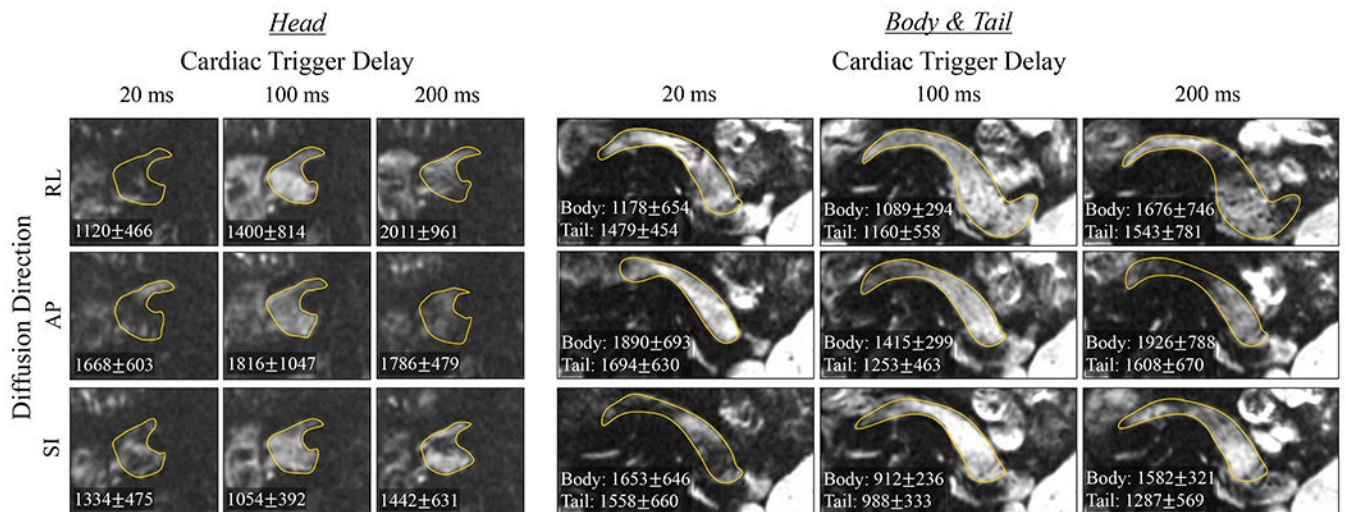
Single-slice monopolar-based diffusion-weighted images with $b = 500 \text{ s/mm}^2$ in three diffusion directions. DWI was obtained at three different cardiac trigger delays, each acquired in a separate breath hold. The yellow contours were drawn from the T2-weighted image ($b = 0 \text{ s/mm}^2$, not shown) and overlaid on DWI $b = 500 \text{ s/mm}^2$ to indicate pancreas location. For each acquisition and each part of the pancreas, the mean and standard deviation of the ADC measured across volunteers are noted in each sub-image. Using monopolar DW gradients, signal dropouts occurred in DWI images in all three parts of the pancreas, in all diffusion directions, and at all trigger delay times, resulting in biased ADC values with a large variation across volunteers observed for each acquisition.
